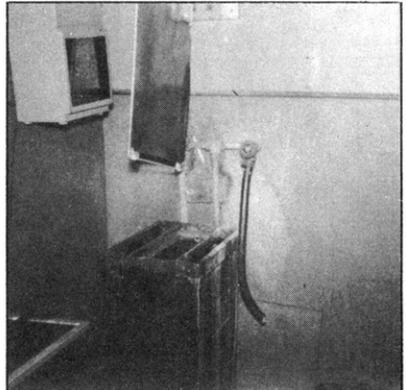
An X-Ray tank and hose on water supply which is submerged when washing negatives.
